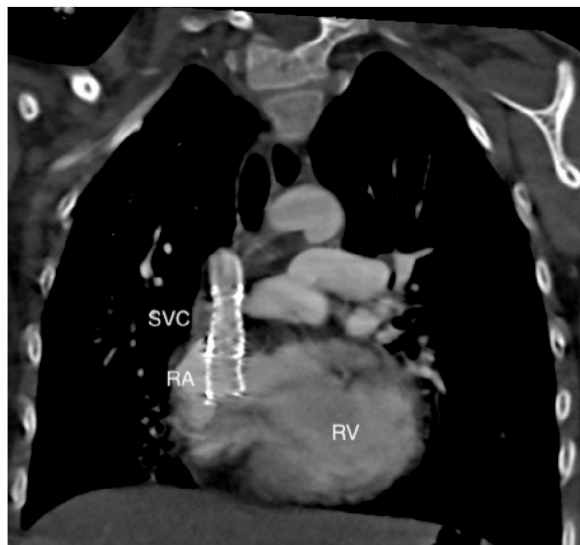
Contrast-enhanced computed tomography paracoronal MPR reconstruction after surgical redirection of superior vena cava into right atrium. Stenosis of surgical anastomoses treated with a metallic stent; SVC = Superior vena cava; RA = Right atrium RV= Right ventricle.
